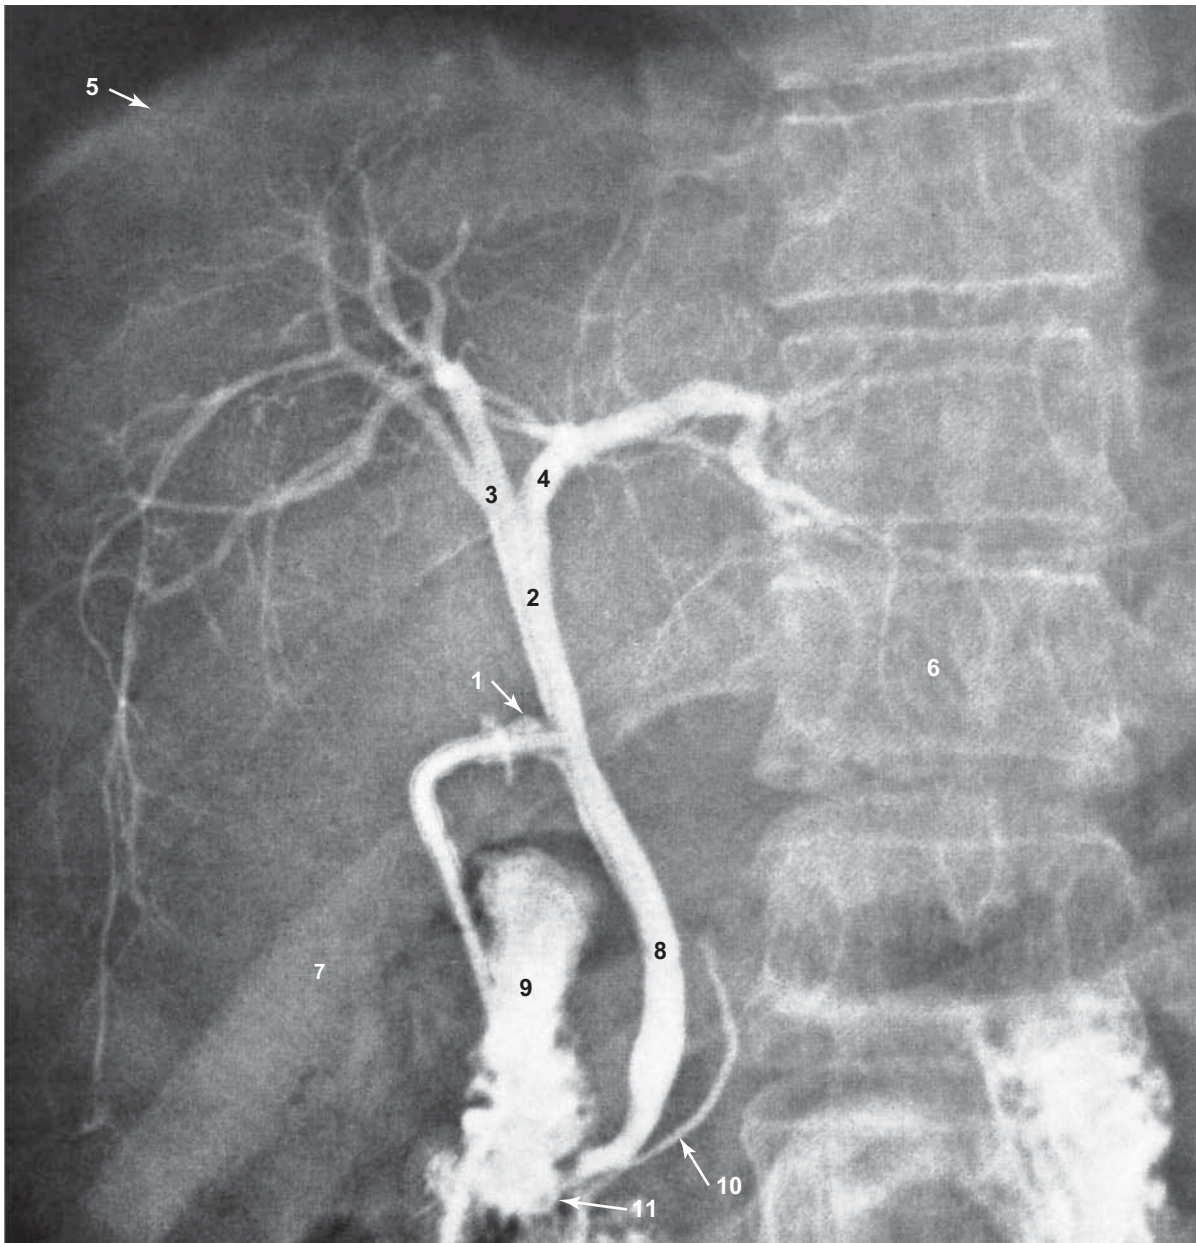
Intraoperative Cholangiogram: Radiograph of Biliary Duct System
